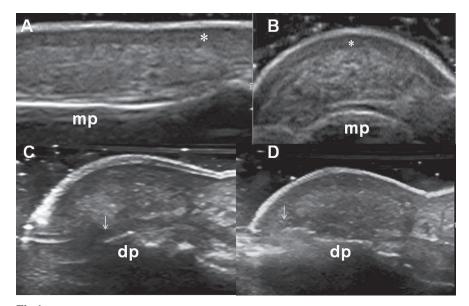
Systemic sclerosis. Dorsal longitudinal (A) and transverse (B) views of the 3rd finger. The asterisk indicates hypoechoic thickening of the derma due to edema. mp = middle phalanx. Images taken using a MyLab70 XVG (Esaote Biomedica, Genoa – Italy) equipped with a 6-18 MHz linear probe. Volar longitudinal views of the right (C) and left (D) 2nd finger with right distal phalanx bone resorption. The arrow indicates distal phalanx edge. dp = distal phalanx. Images taken using a Logiq 9 (General Electrics, Milwakee – USA) equipped with a 15 MHz linear probe. For further ultrasound images, go to www.clinexprheumatol.org/ultrasound
